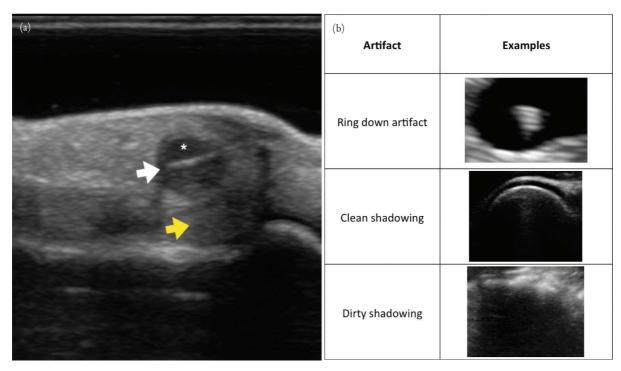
(a) Typical appearance of foreign body on ultrasound. This is a wood splinter lodged in the patient's finger on the palmar side. The splinter is seen as a hyperechoic linear mass (white arrow). Surrounding the splinter is a hypoechoic "halo" signifying adjacent edema, inflammation, and/or hemorrhage. Note that deep to the splinter, there is show shadowing artifact (yellow arrows). (b) Artifacts associated with foreign bodies on ultrasound. Ring down artifact is due to resonation of the original sound wave on the foreign body, thus leading to the repeated horizontal lines seen deep to the mass. Clean shadowing or attenuation artifact is the inability of the sound wave to penetrate through the dense mass, thus leading to an anechoic band deep to the mass. Dirty shadowing refers to scattering of sound waves off the mass, so that a mostly anechoic band is seen intermixed with transient hyperechoic textures.
